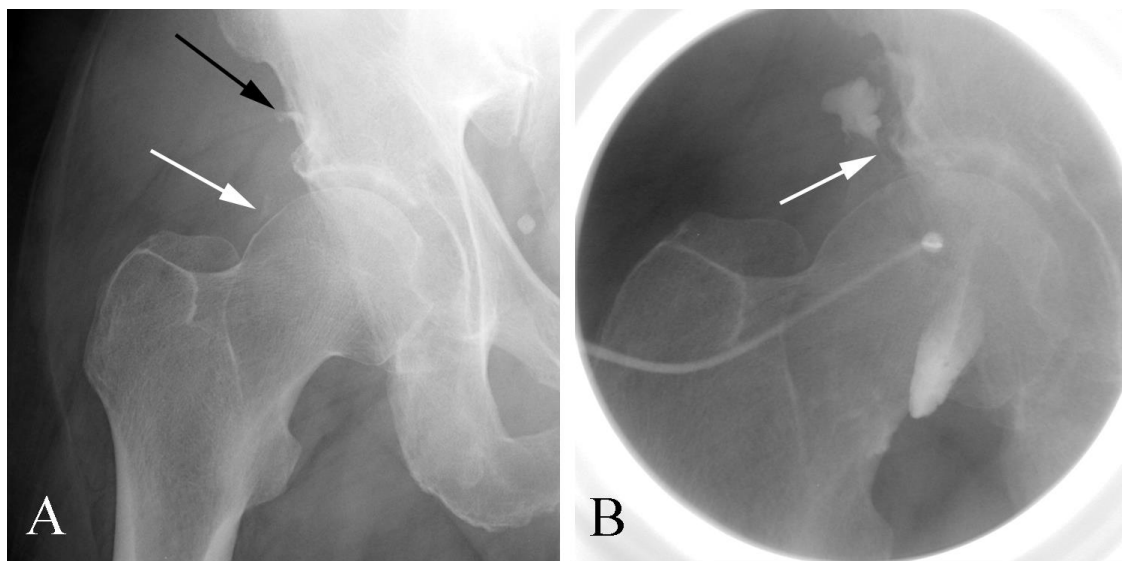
Gout of the right hip in a 70 year old man with chronic hip pain. A. Plain film examination shows calcification along the margin of the femoral head (white arrow). There is erosion with an overhanging edge along the lateral acetabulum (black arrow). B. Hip arthrogram shows contrast along the synovial extension adjacent to the acetabulum through a narrow connection along the femoral head (arrow).
